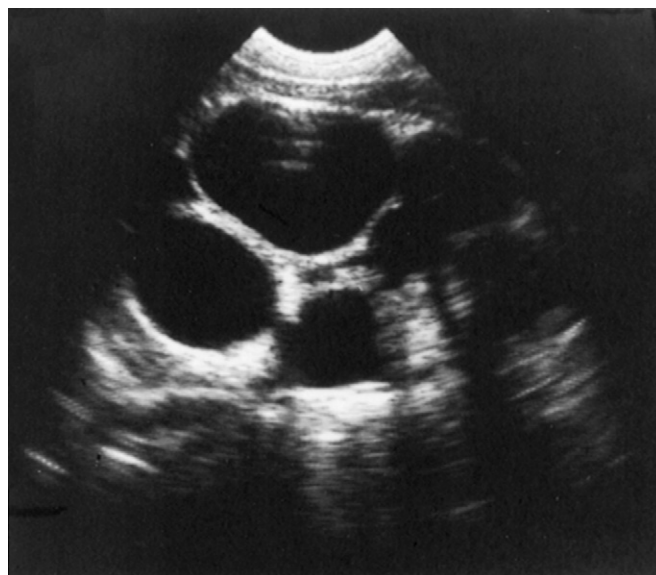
Typical ultrasound appearance of a multicystic kidney. Three large cysts are seen, with some smaller cysts in between. Little parenchyma is identified.
